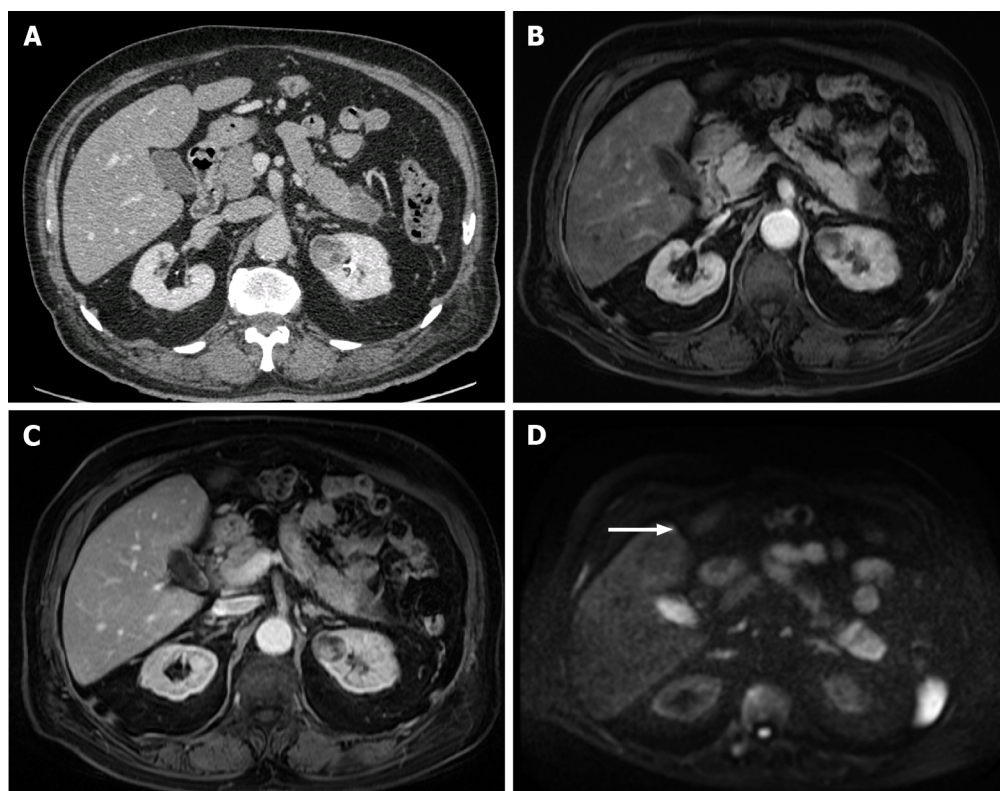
A 40-year-old woman with breast cancer showing a subcapsular millimetric iso-vascular metastasis only depicted in the diffusion-weighted imaging. Contrast-enhanced computed tomography (CE-CT) and dynamic magnetic resonance imaging (MRI) sequences could not detect the lesion. A: Axial CE-CT in the portal-venous phase; B: Axial fat saturated (FS) CE-MRI T1-weighted imaging (WI) in the arterial phase; C: Axial FS CE-MRI T1-WI in the portal-venous phase; D: Diffusion-weighted imaging showing a small lesion with high signal intensity on high *b* value corresponding to liver metastasis (arrow).
